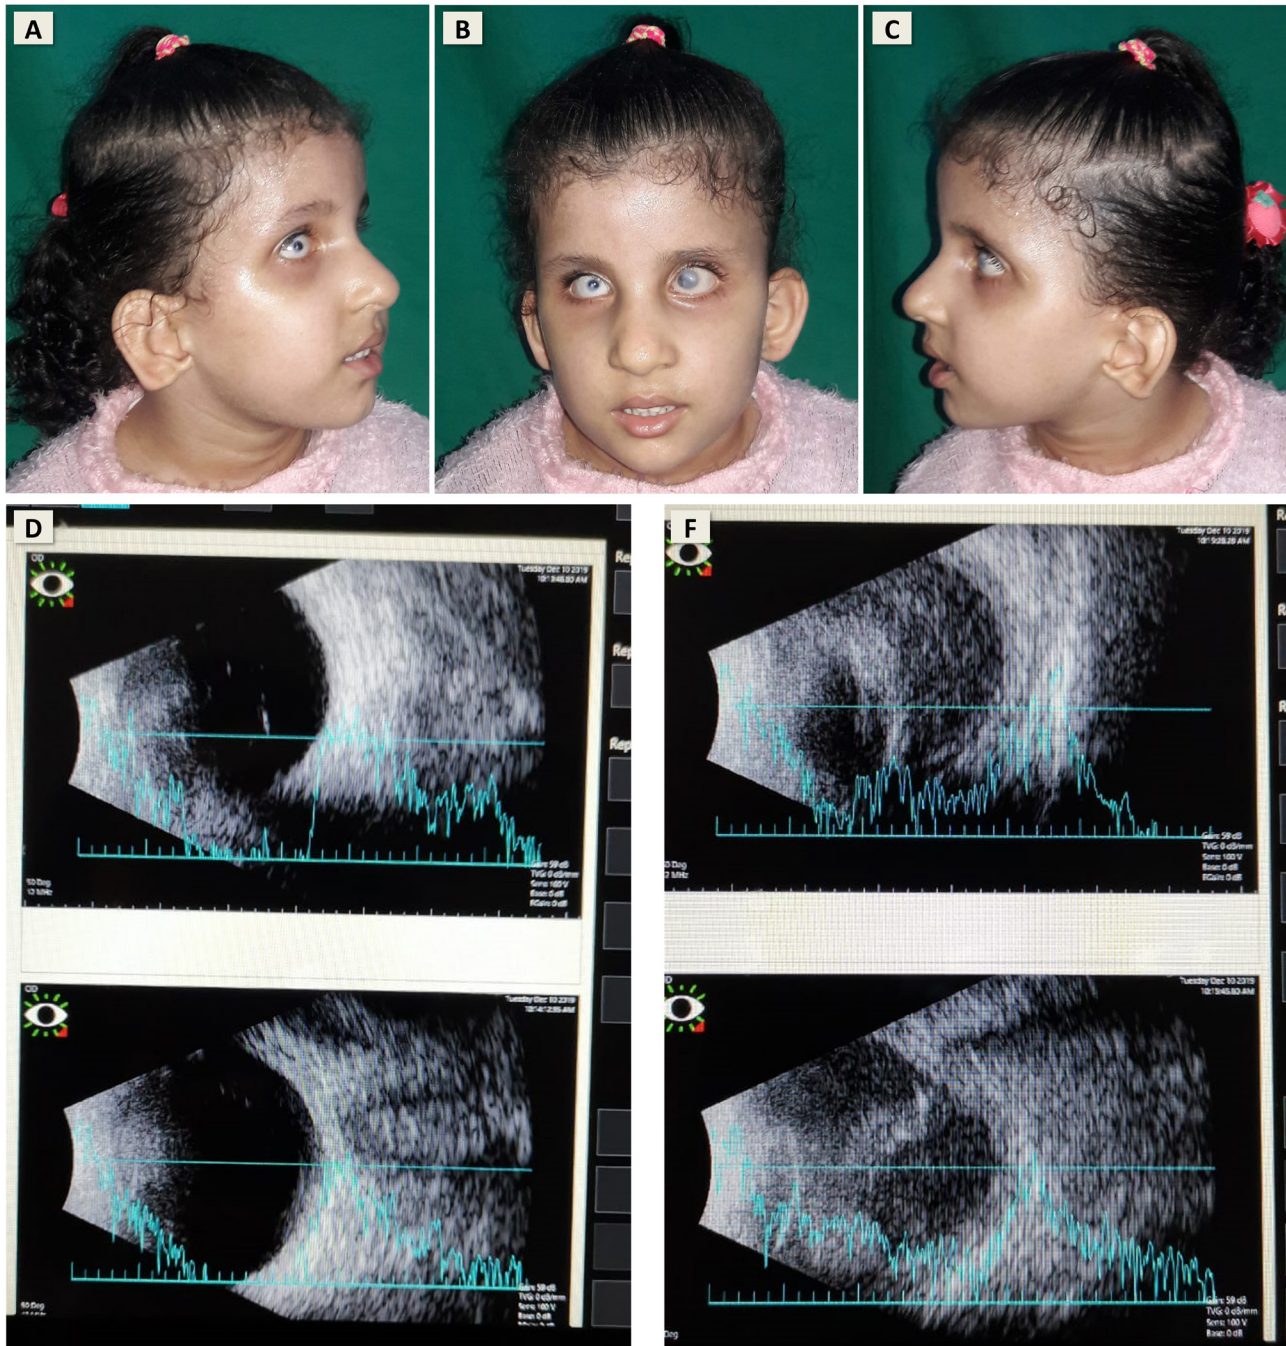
Clinical and ultrasonographic features of patient P24 with 'oculoauricular syndrome' Upper panel A-C: Clinical photos demonstrating excessive sweating in cold weather, a long face and protruded low-set ears with lobule aplasia, deeply set eyes, convergent squint, scanty eyebrows, microphthalmia with adherent central corneal leukoma in right eye and total corneal leukoma in left eye. Lower panel D, E: B-scan ultrasonography revealing retina in place with sonoluscent vitreous cavity in right eye and closed funnel retinal detachment in the left eye.
